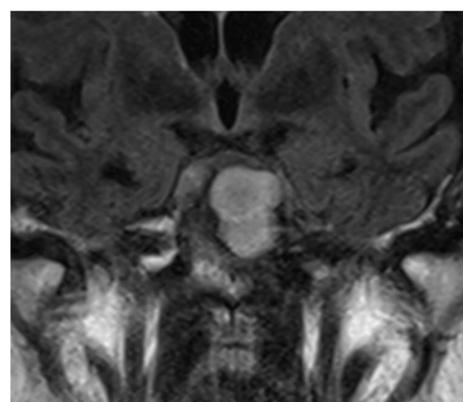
MRI with homogeneous signal intensity of the sphenoid mucocele
